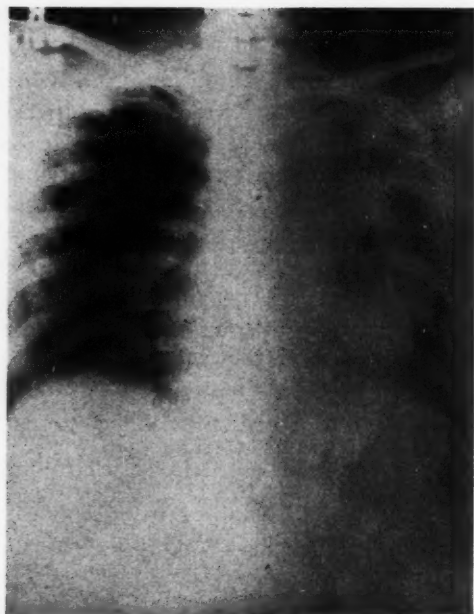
Roentgenogram of the chest (February 21, 1931).
